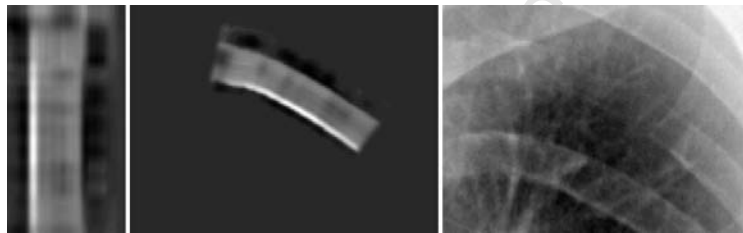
Results of rib suppression by Hogeweg et al. (2010b). The left image shows the modelled rib greyscale values, the middle image the model as fitted to the chest X-ray and the right image the rib suppressed area.
